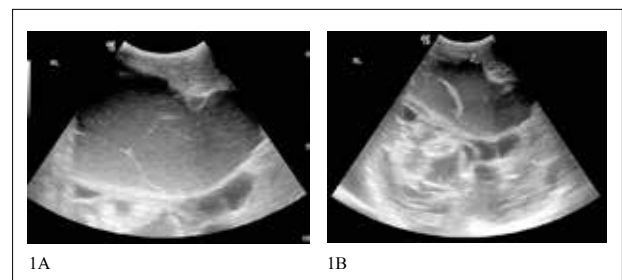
Ultrasound of the upper abdomen demonstrates a large mixed solid and cystic lesion in the right upper quadrant of the abdomen.
